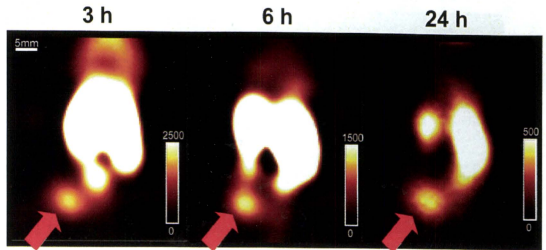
インビボカップリング法による MT1-MMP 発現腫瘍の経時的 SPECT 画像 (矢印が腫瘍で、投与 3 時間後から明瞭に描出されている)
